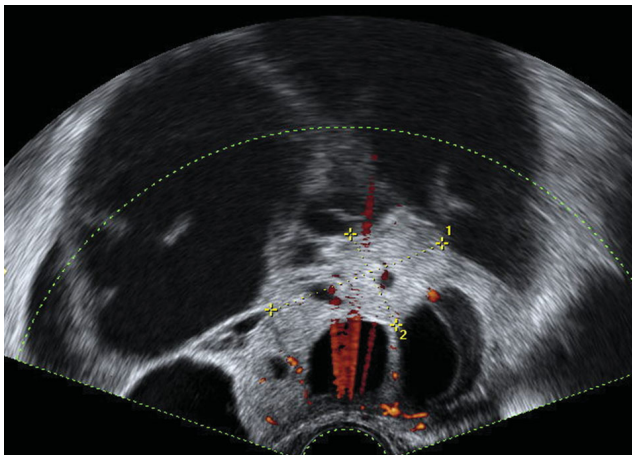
Ovarian metastases from stomach carcinoma (a, highly vascularized) and breast carcinoma (b, moderately vascularized) on color Doppler evaluation.
